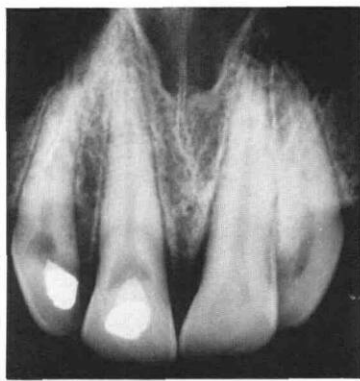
An 18-month post-treatment radiograph of treated central and lateral incisors which shows areas of internal resorption replacing the dentin bridges.
